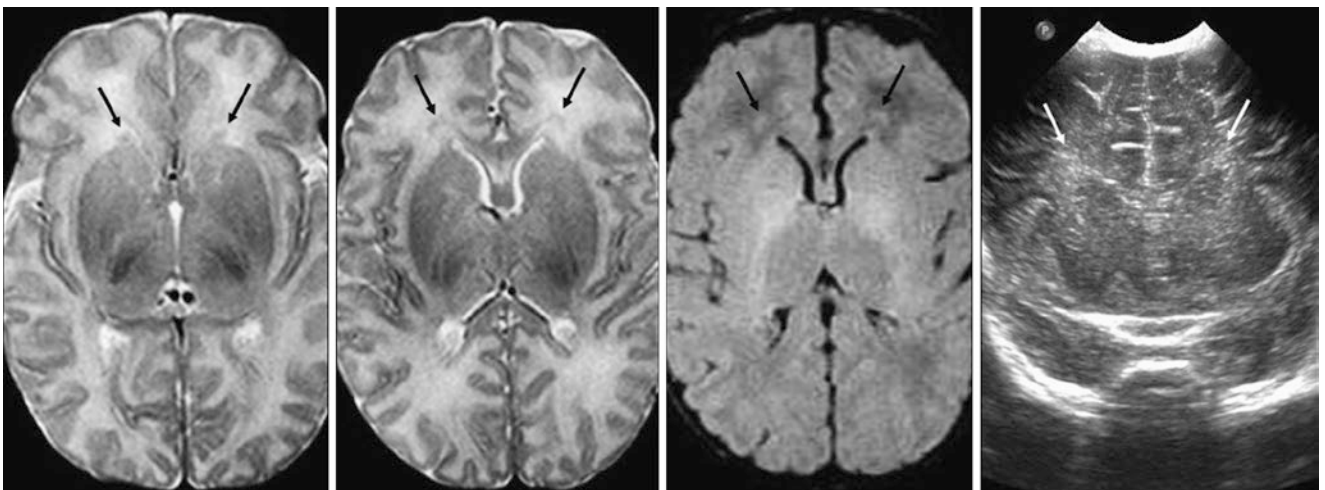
A 40-week-old term infant had presumed RGM (*thin arrows*) on a 1.5T MRI with SE T2WIs (*left and left middle*), which were also visualized on FLAIR (*right middle*). DWI (*not shown*) and a
